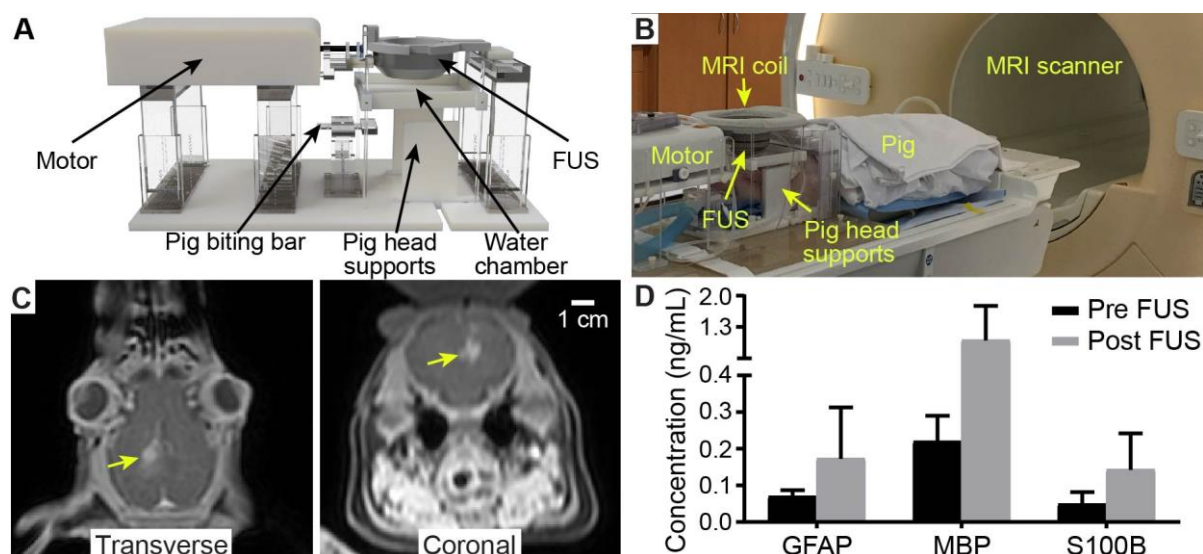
A) 3D rendering of MR-compatible FUS-LBx system. B) Picture of experimental setup. C) Contrast-enhanced T1-weighted MR images verified successful BBB opening (yellow arrow). D) FUS-LBx enhanced the release of brain-specific biomarkers (GFAP, MBP, and S100B).
